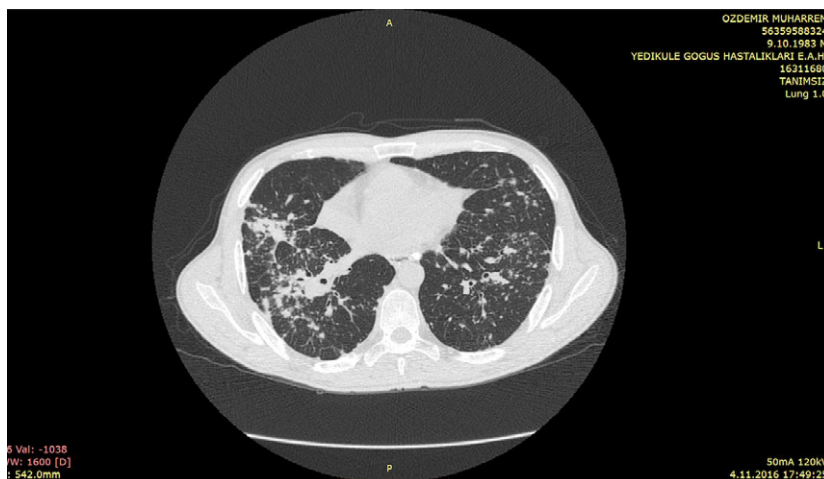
Basal high-resolution computed tomography.
